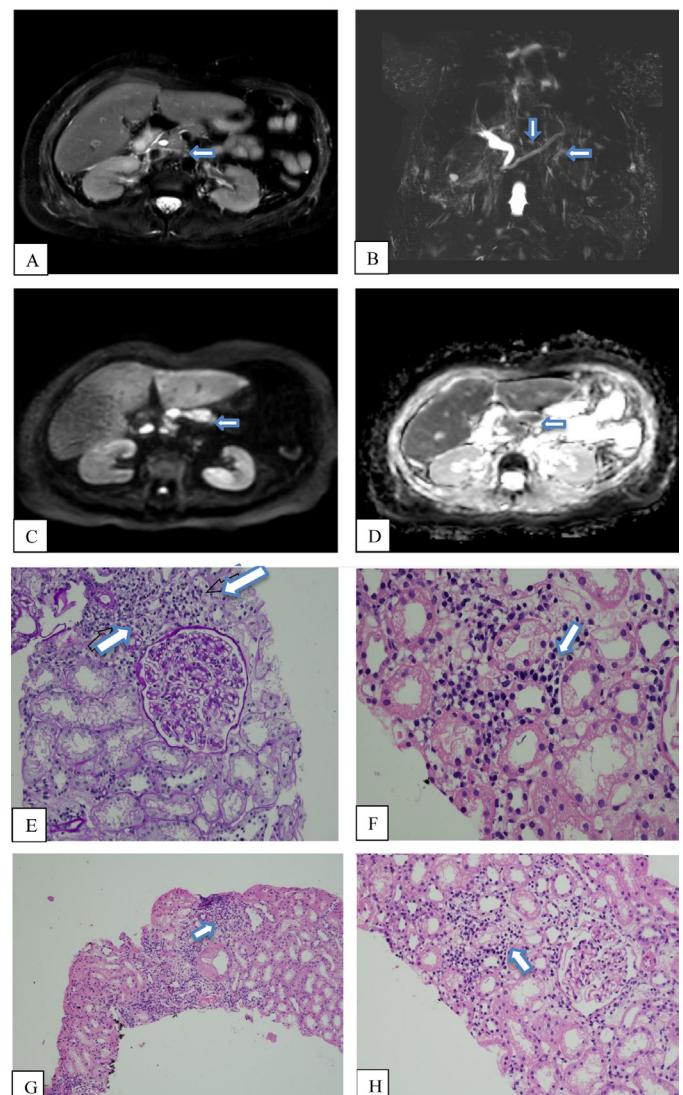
(A) T2W axial images show mild peripancreatic stranding. (B) Maximum intensity projection (MIP) coronal MRCP shows peripancreatic inflammation. (C) Axial diffusion-weighted imaging (DWI) shows areas of diffusion restriction in the pancreatic parenchyma. (D) Corresponding signal drop on ADC images. (E) PAS 10× → Interstitial lymphoplasmacytic infiltrate; (F) HE 20× → Plasma cell rich tubulointerstitial nephritis. (G) HE 10× → Interstitial lymphoplasmacytic infiltrate with mild tubulitis. (H) HE 20× → Interstitial lymphoplasmacytic infiltrate with normal glomerulus.
